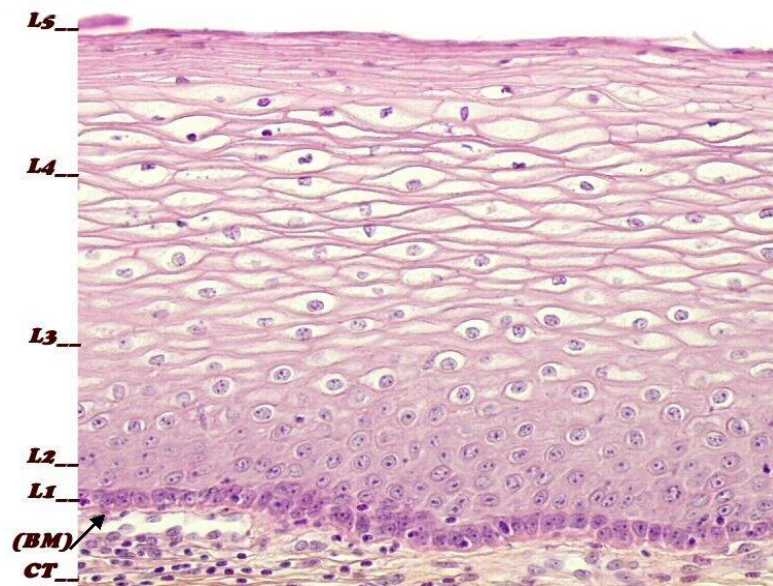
Structure of the ectocervix. CT = connective tissue, BM = basement membrane, L1 = basal cells, L2 = parabasal cells, L3 = intermediate cells, L4 = superficial cells, L5 = exfoliating cells (IARC, 2014).
